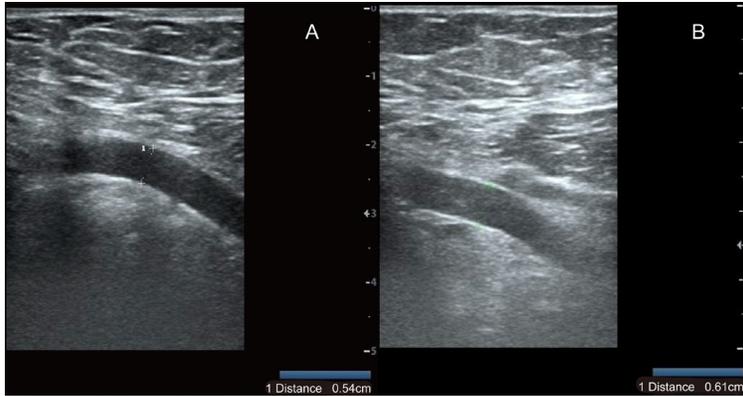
Typical Doppler images of axillary artery in patients, with and without lymph node metastasis. (A) Doppler ultrasound image of the axillary artery in a patient without lymph node metastasis. The vessel appears normal, with no signs of abnormal flow or structural changes; (B) Doppler ultrasound image of the axillary artery in a patient with lymph node metastasis. Structural changes and altered blood flow are visible compared to the normal appearance in (A).
